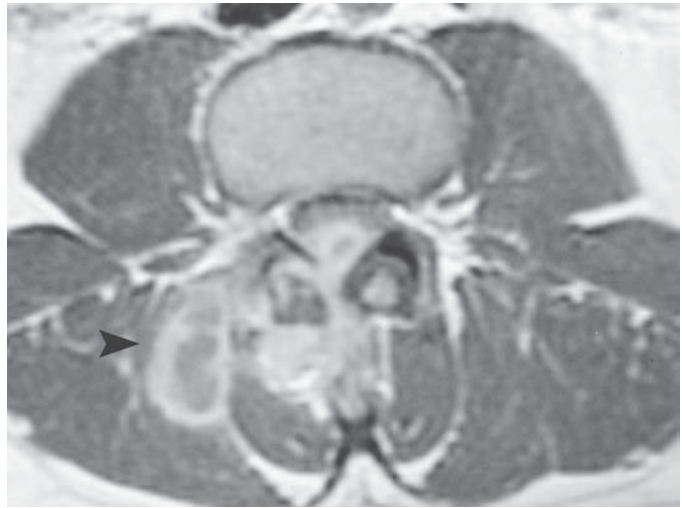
Tuberculous infection. Axial post-contrast T1-weighted image in a patient with tuberculous spondylitis reveals a paravertebral abscess (arrowhead), dorsal epidural abscess, and involvement of the posterior elements.
